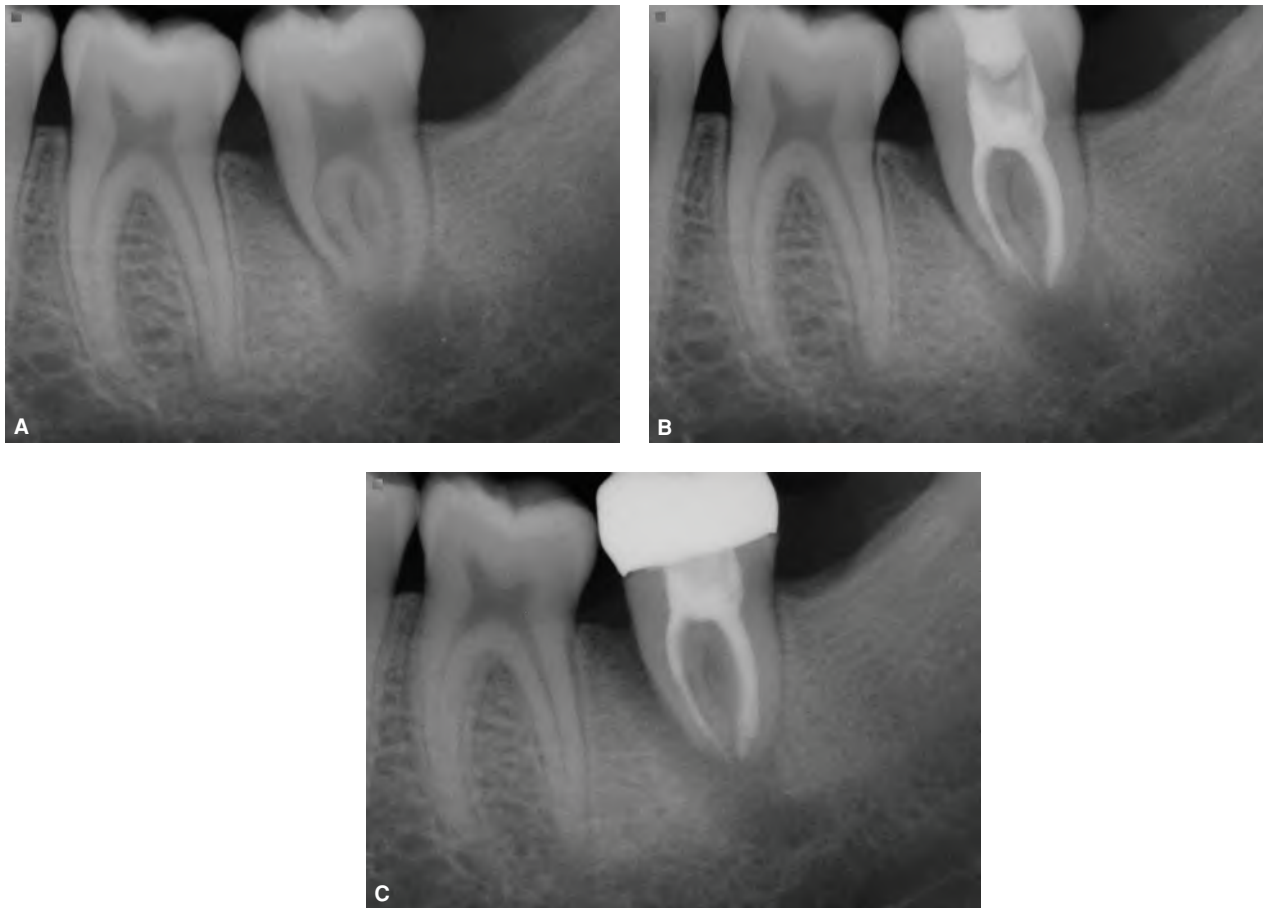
A. Lower left second molar with nonvital pulp and no apparent reason for necrosis other than possible root fracture. Note extensive periapical bone loss with some vertical bone loss on the mesial aspect of the root. B. One year after endodontic treatment. Note increase in periapical and vertical bone loss. C. Two years after endodontic treatment a substantial increase in periapical and vertical bone loss is observed. The tooth was extracted and the presence of a vertical root fracture was confirmed.
